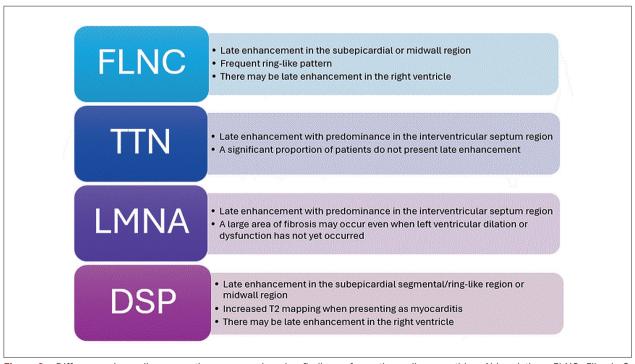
Differences in cardiac magnetic resonance imaging findings of genetic cardiomyopathies. Abbreviations: FLNC: Filamin C; TTN: Titin; LMNA: Lamin A/C; DSP: Desmoplakin.
